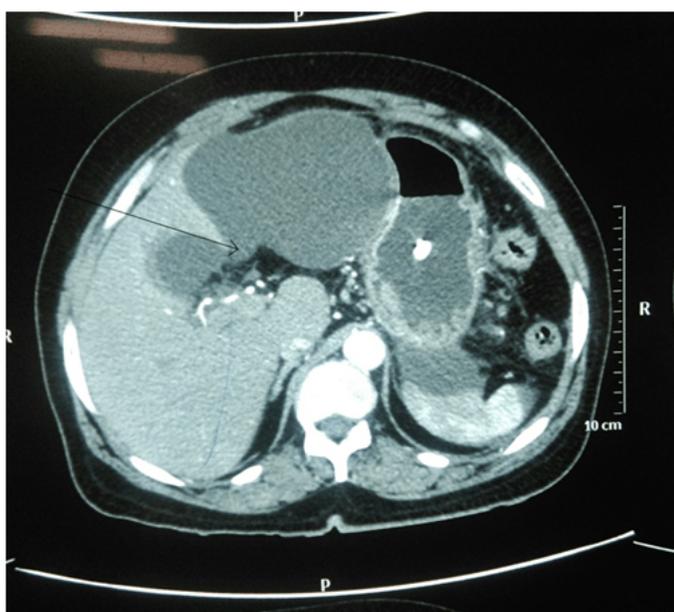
Contrast-enhanced computed tomography scan of abdomen showing collection (arrow) in gallbladder fossa.
